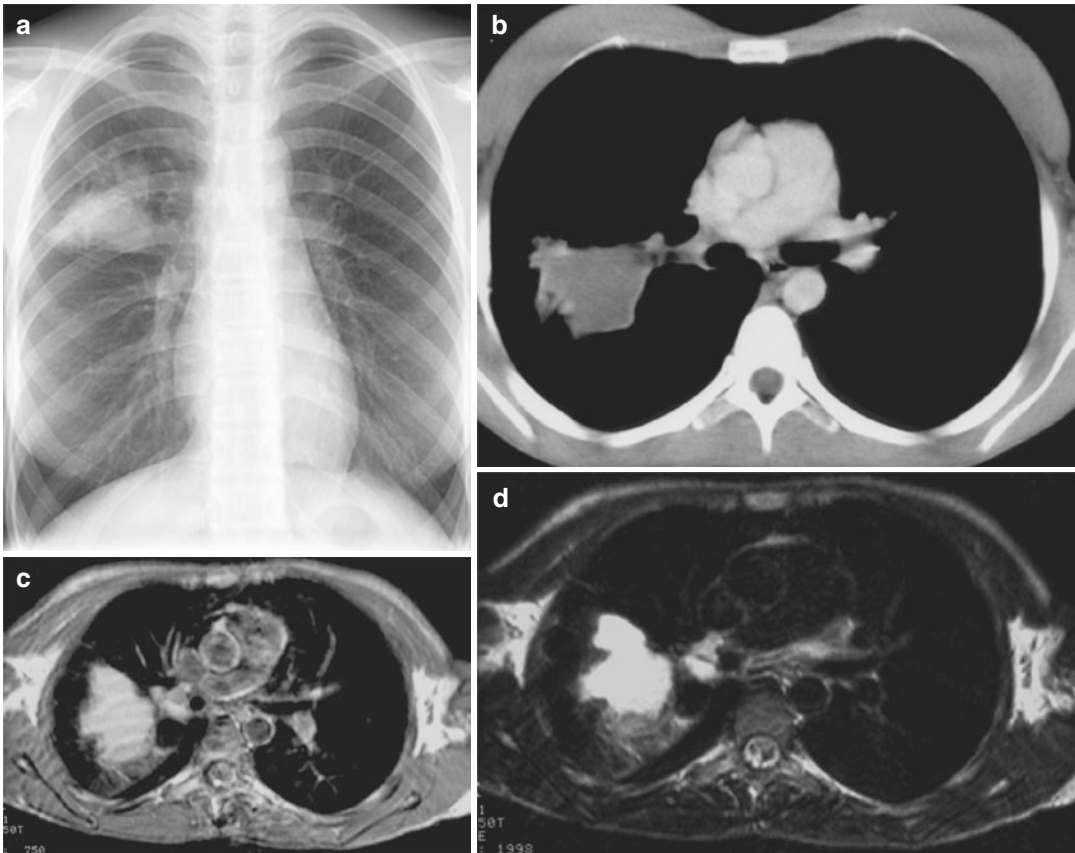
A 15-year-old female with bronchocele in the right upper lobe. Chest radiograph shows a mass in the right upper lung field (a). Contrast-enhanced CT shows a mass with water density in the right upper lobe (b). Conventional T1-weighted SE (c) and T2-weighted turbo
